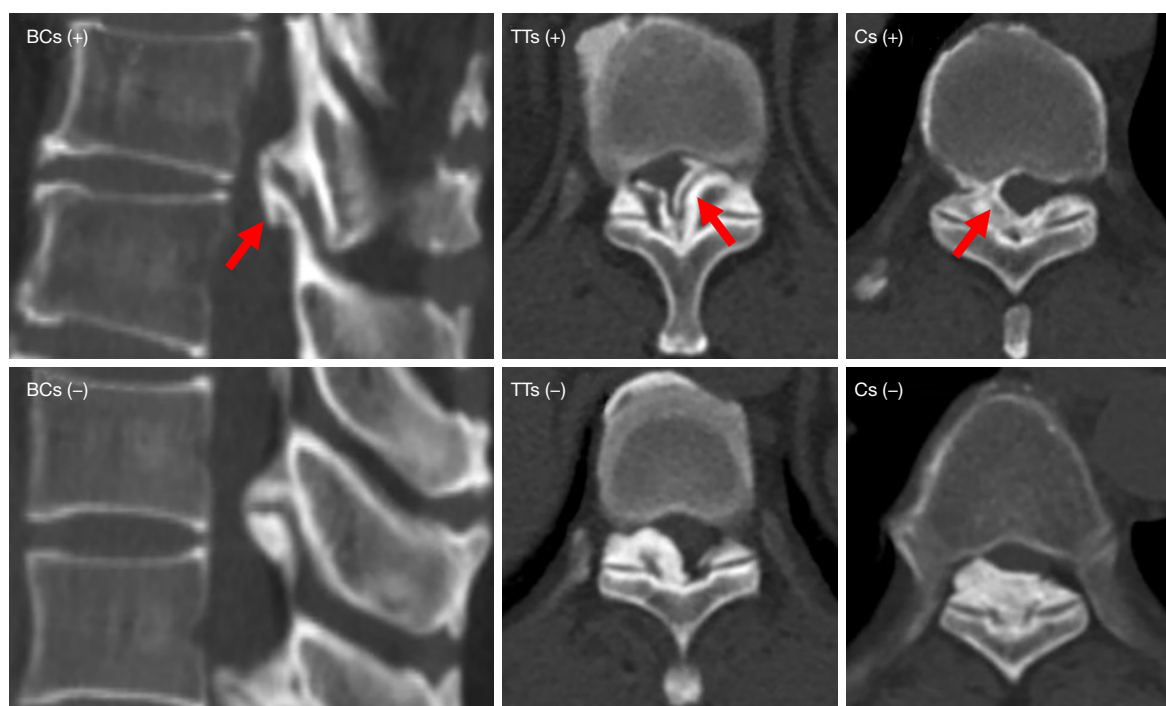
The representative CT images of BCs (left panel), TTs (middle panel) and Cs (right panel). For each typical imaging sign, (+) indicates positive and (-) indicates negative. The red arrows indicate the differences between these imaging signs. BCs, Banner cloud sign; TTs, tram-track sign; Cs, comma sign; CT, computed tomography.
